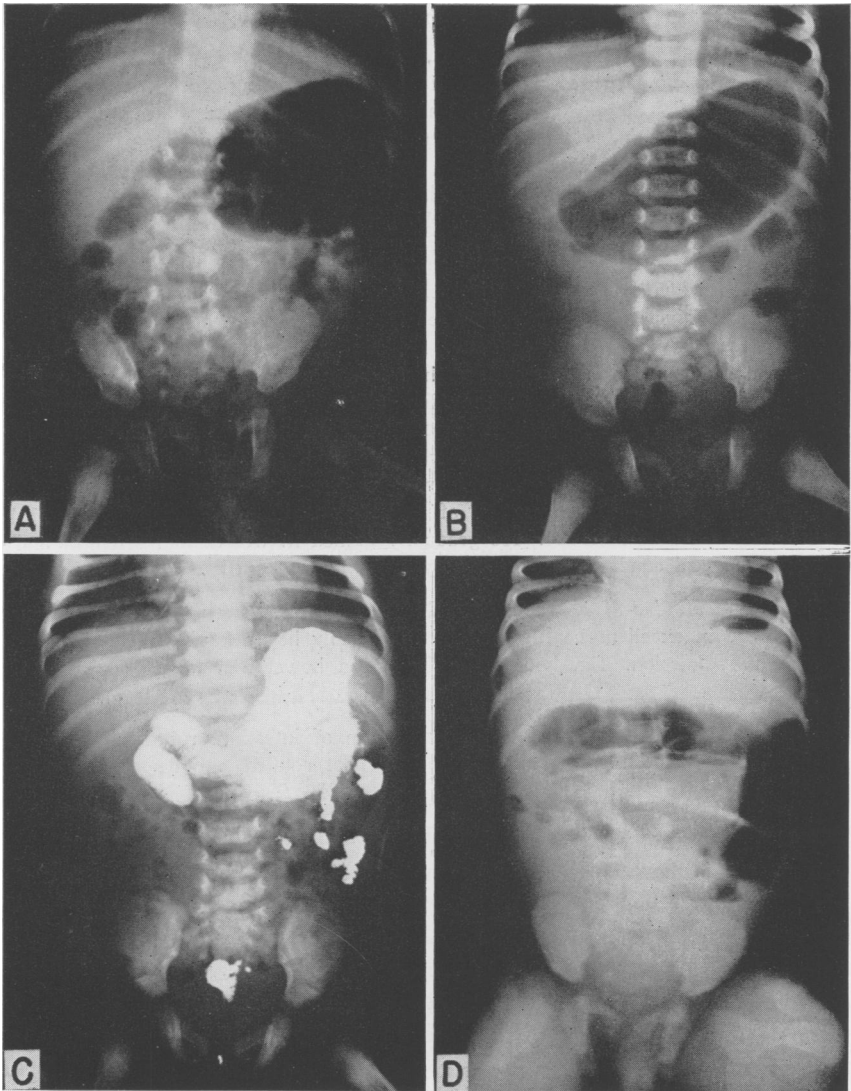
Roentgen rays of the abdomen in four infants with volvulus of the midgut is shown. (A)—Case 2. A 2-month-old infant with signs of chronic duodenal obstruction since birth. The stomach is distended with air and there is some gas in the bowel. (B)—Case 3. A 5-day-old infant with a story of biliary vomiting since birth. The stomach is distended with air. There is also a little gas in the colon, probably introduced by enema. (C)—Case 4. A 9-day-old infant with vomiting since birth who had been operated upon elsewhere on the fourth day for pyloric stenosis, but none was found. He was given barium by mouth 24 hours before being sent to us. This roentgen ray shows 24-hour retention of barium in stomach and duodenum with passage of a small amount of barium into the intestinal tract. (D)—Case 5. A 6-week-old infant with signs of acute intestinal obstruction of 12 hours duration. He had had three bloody bowel movements and was thought to have an intussusception before operation. The roentgen ray shows dilated loops of bowel full of gas in the left upper abdomen.
